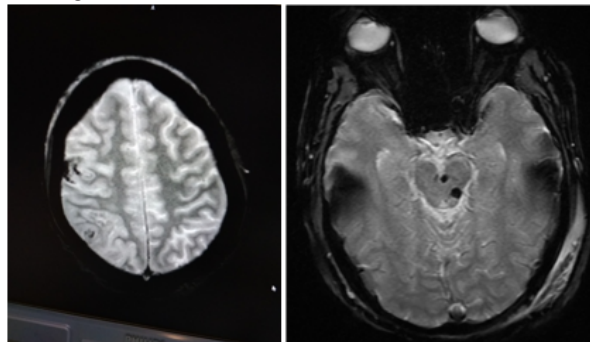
MRI shows small foci of bleed suggests Diffuse Axonal Injury (DAI)
